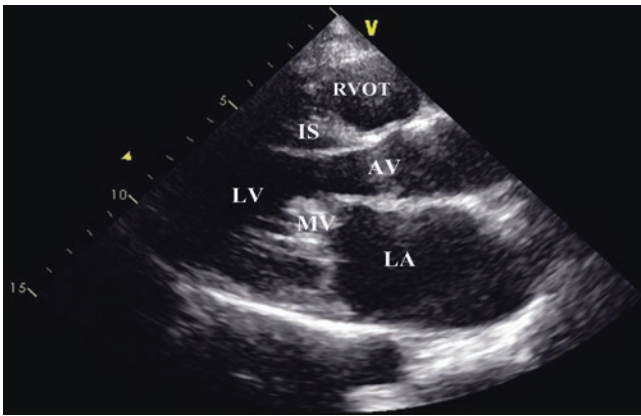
Mitral stenosis, parasternal long axis view. Mitral valve can be visualized from multiple views. In parasternal long axis view, the left atrium (LA), left ventricle (LV), right ventricular outflow tract (RVOT) and interventricular septum (IS) are seen. Aortic valve (AV) appears echo dense but it is opening normally. Mitral valve (MV) appears echo dense and thickened with highly restricted leaflet opening. This is consistent with rheumatic mitral valve stenosis. See also Video 20.1
